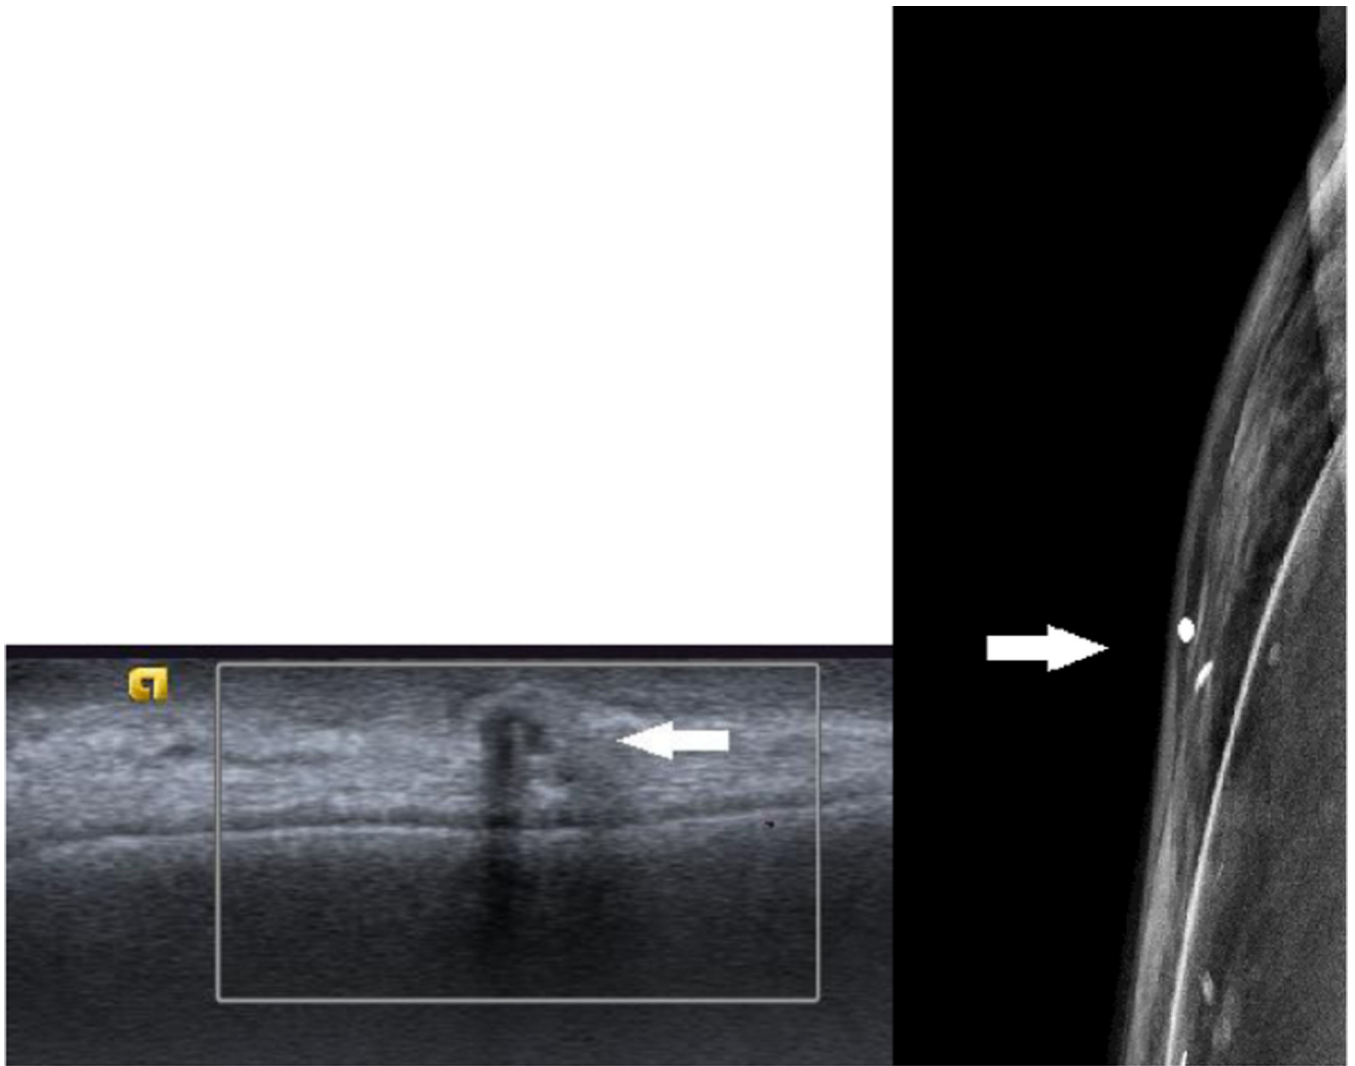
Patient status post-mastectomy with implant reconstruction. Palpable mass which on ultrasound (3a) was anechoic with no vascularity and dense posterior shadowing (arrow). Cone mammographic view (3b) confirmed this was a calcification.
